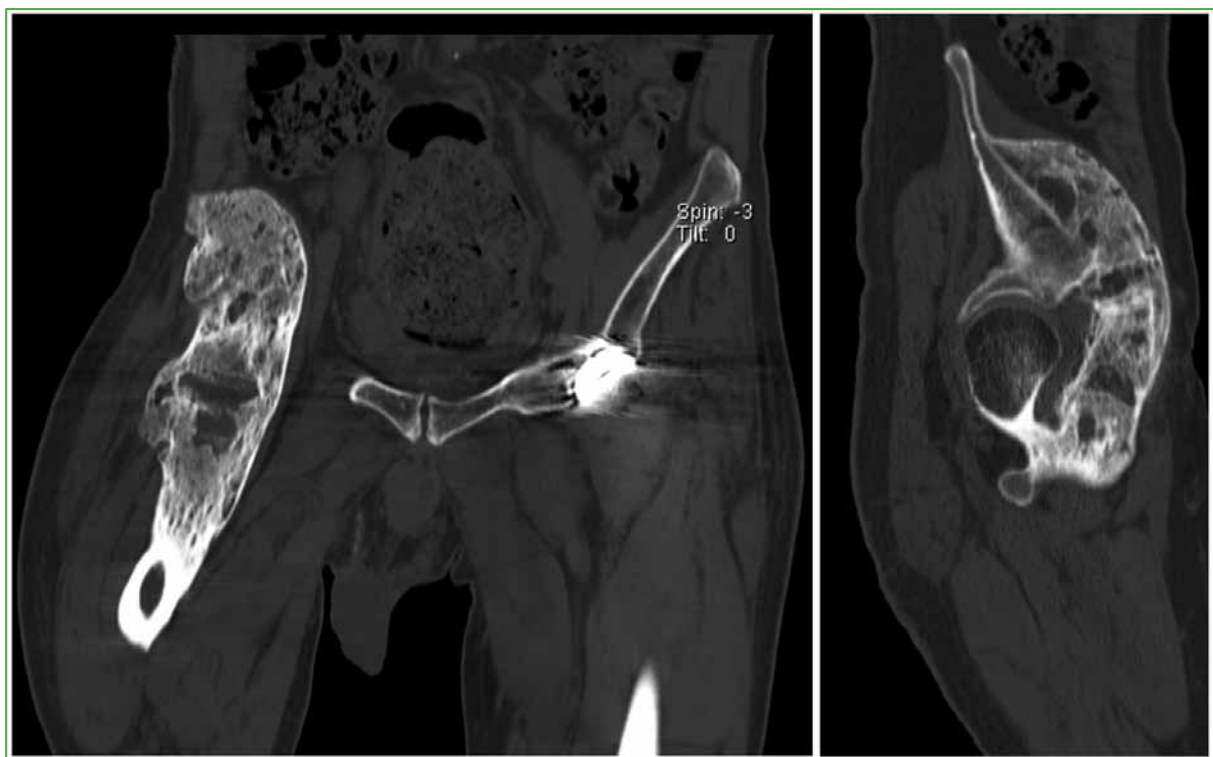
Computed tomography of the pelvis. Heterotopic ossification formation with bony bridging from the femoral neck to the iliac crest at the level of the non-operated hip. Brooker classification grade IV.⁸
